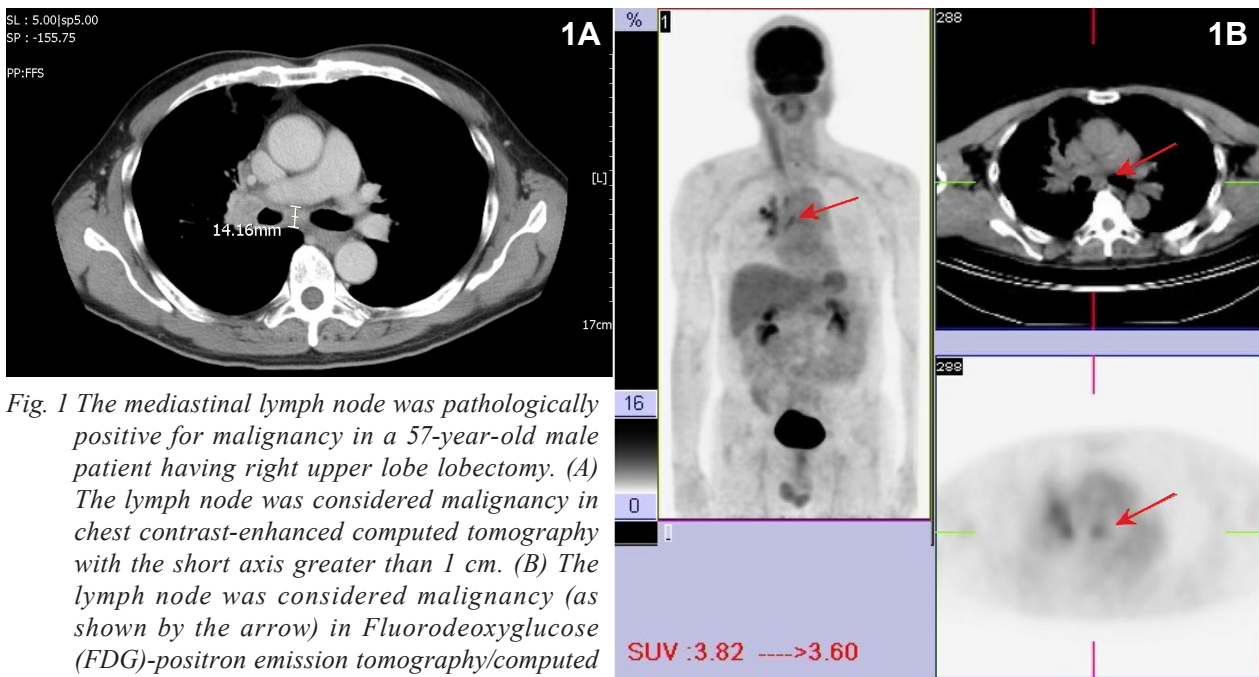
The mediastinal lymph node was pathologically positive for malignancy in a 57-year-old male patient having right upper lobe lobectomy. (A) The lymph node was considered malignancy in chest contrast-enhanced computed tomography with the short axis greater than 1 cm. (B) The lymph node was considered malignancy (as shown by the arrow) in Fluorodeoxyglucose (FDG)-positron emission tomography/computed tomography with the SUV_{max} greater than 2.5.
